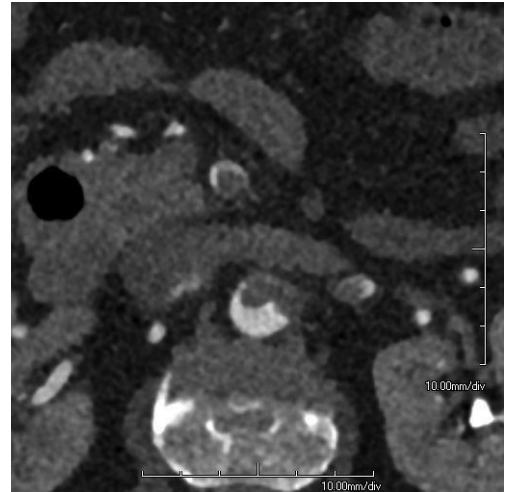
CTA image of CA thrombosis.
